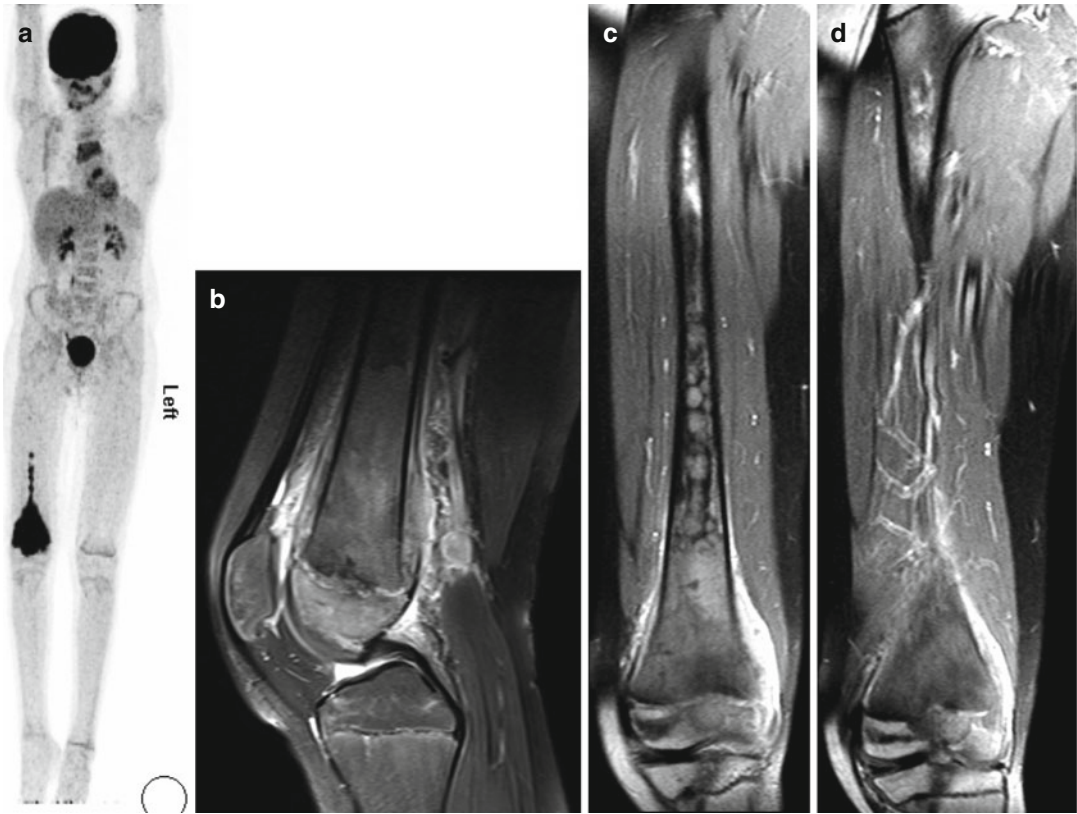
A 13-year-old boy with an osteosarcoma of the right distal femur. 3D reconstructed ^{18}F -FDG PET (a) shows high glucose metabolism in the metaphysis and epiphysis of the right femur. Bone marrow extension can be seen up to the middle part of the femur. However, MRI (b–d) is indispensable for delineation of soft tissue involvement and bone marrow extension.
